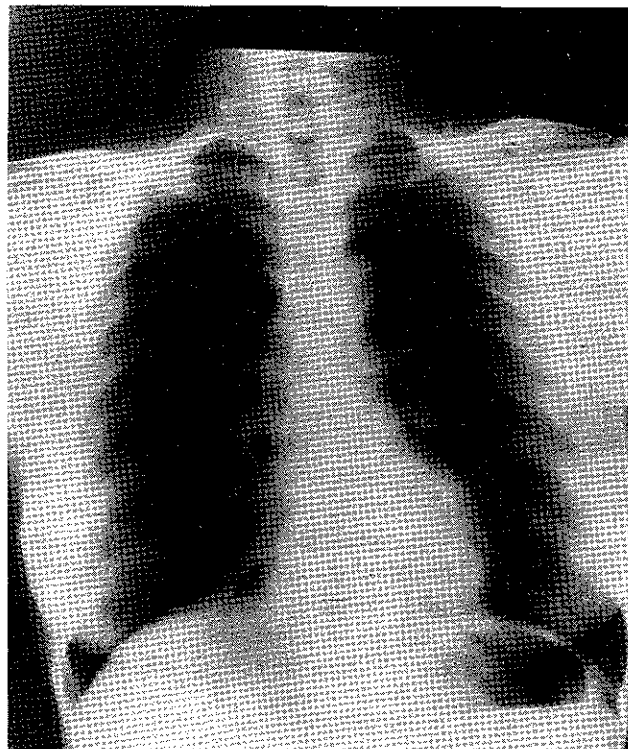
Chest x-ray of the patient showing no demonstrable pathology.
